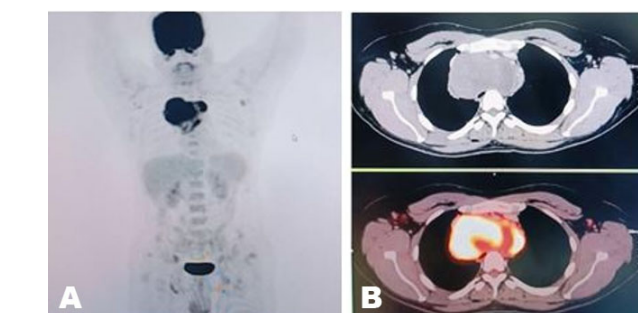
(A) Topographic image of index PET-CT with metabolically active mediastinal mass. (B) Cross-sectional image of index PET-CT s/o FDG avid mediastinal mass.
